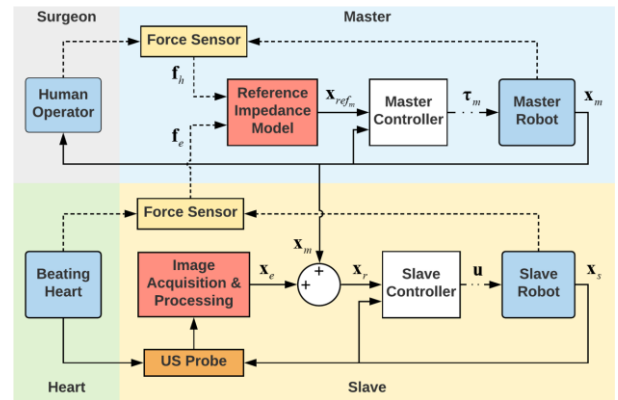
The telerobotic beating-heart surgical system with robot impedance-controlled force feedback and ultrasound image-based motion compensation.
